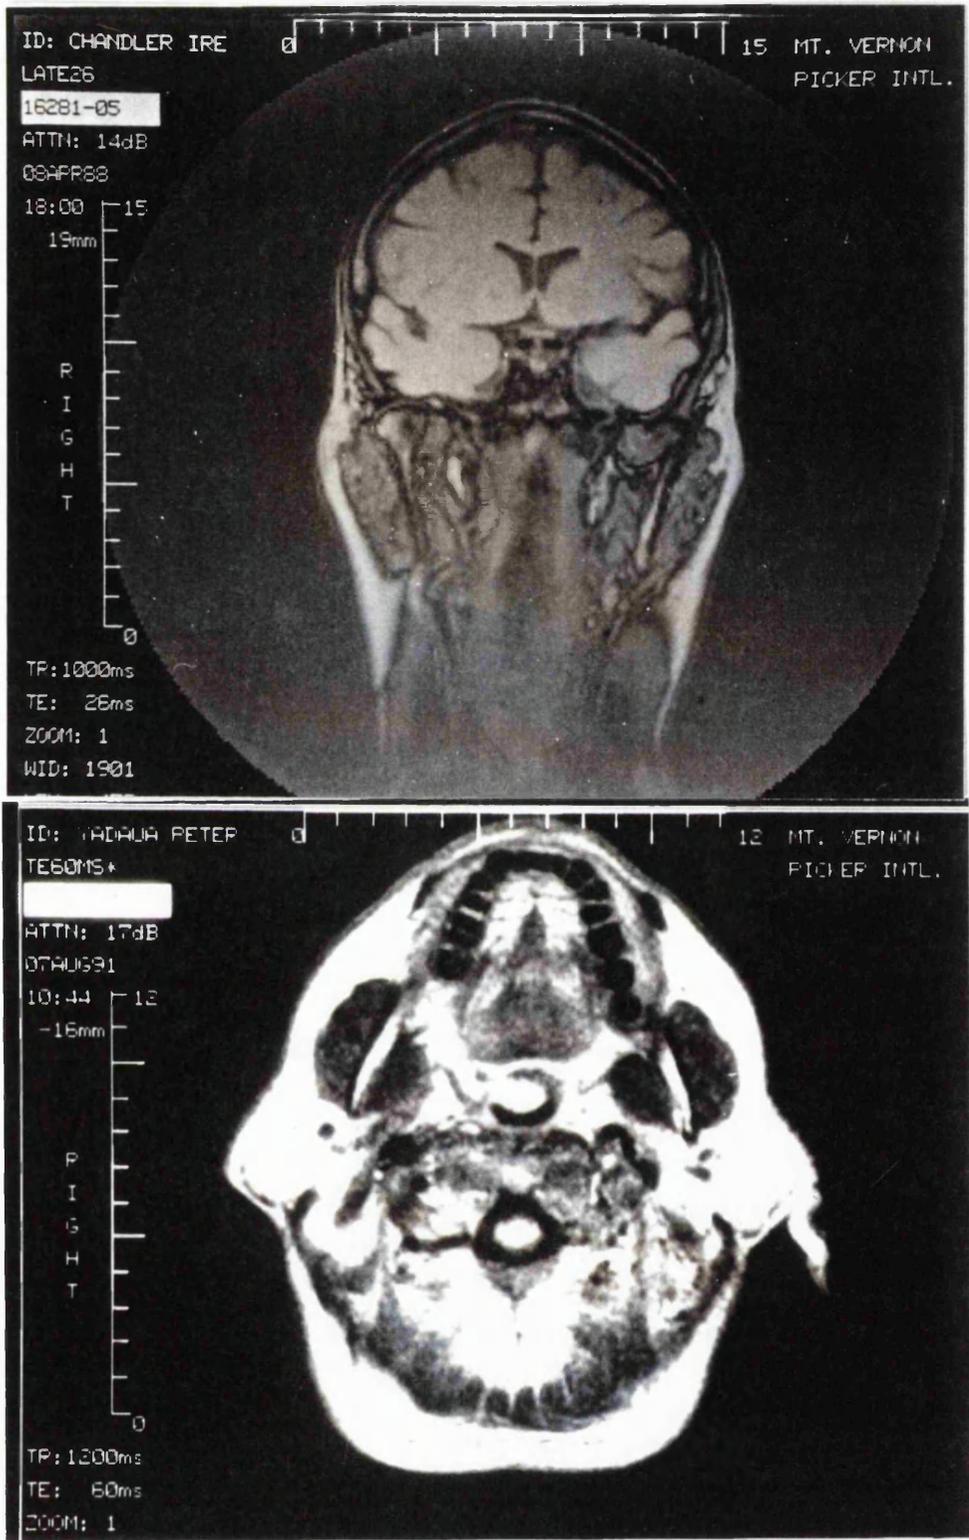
Parotid gland demonstrated by MRI.
